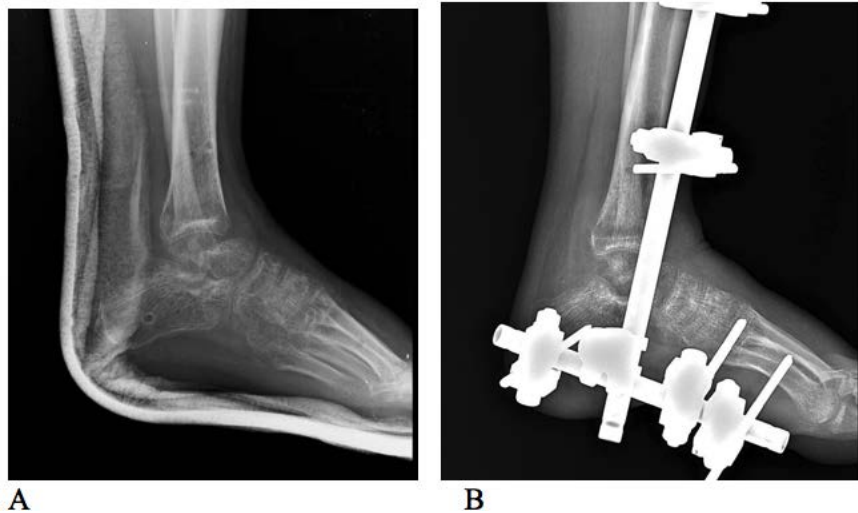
The lateral radiograph of right ankle demonstrating talar body loss (A), followed by staging with the joint spanning external fixator (B).
